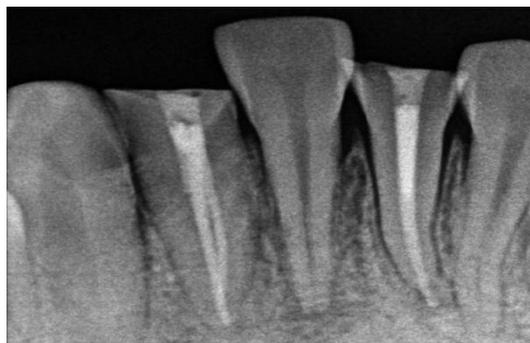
Radiograph showing obturation of 31,42
